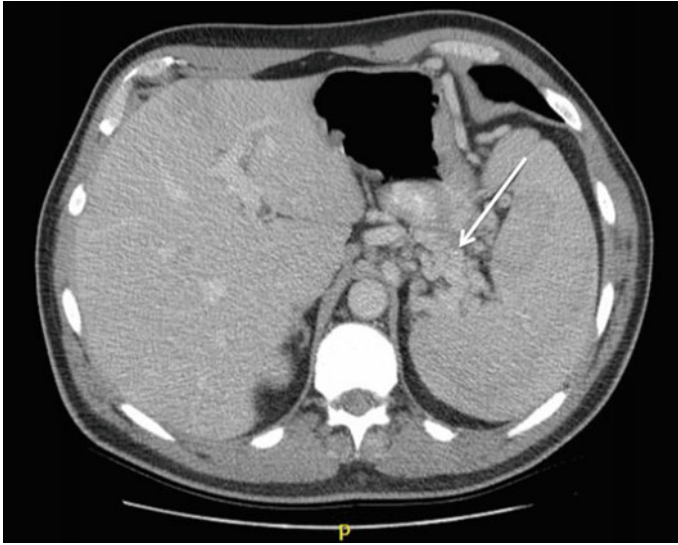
CT scan demonstrating pancreatic tail mass
